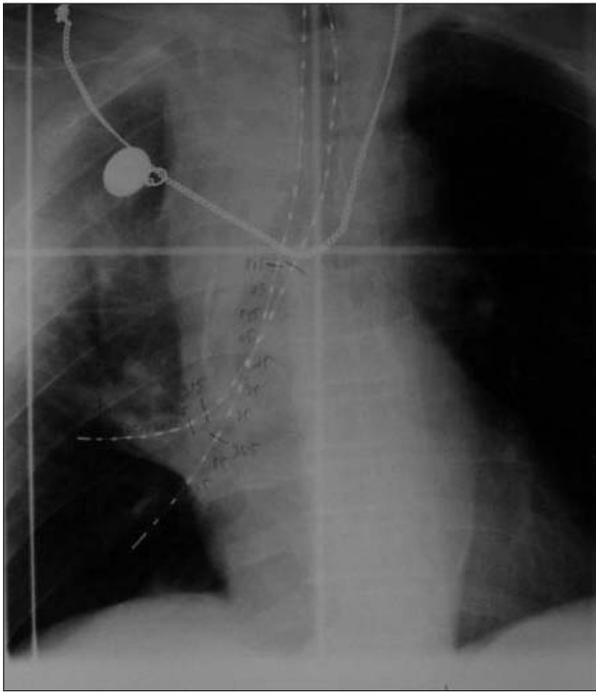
Radiograph: two endobronchial catheter inserted.
